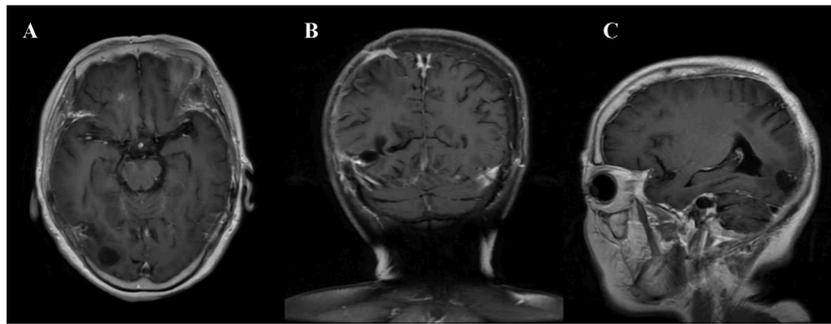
Follow-up contrast-enhanced MRI at 6 months, A (T1W transverse axis), B (T1W coronal) and C (T1W sagittal) showed substantial resolution of the lesions and surrounded oedema.
